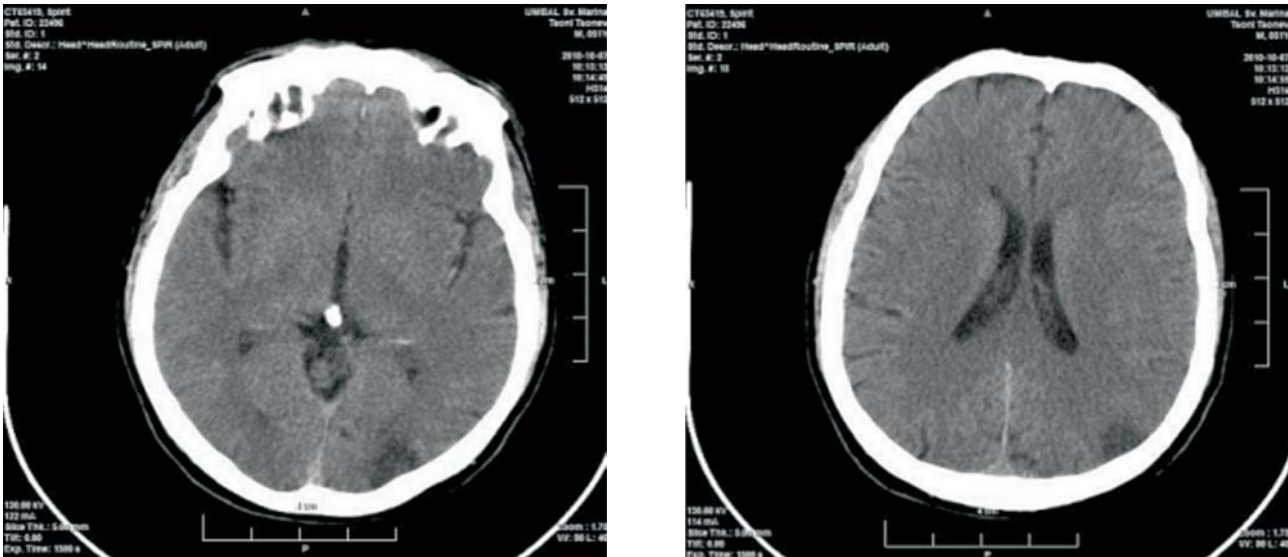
Control CT (10.15 h) to exclude intracerebral haemorrhage NIHSS = 15
